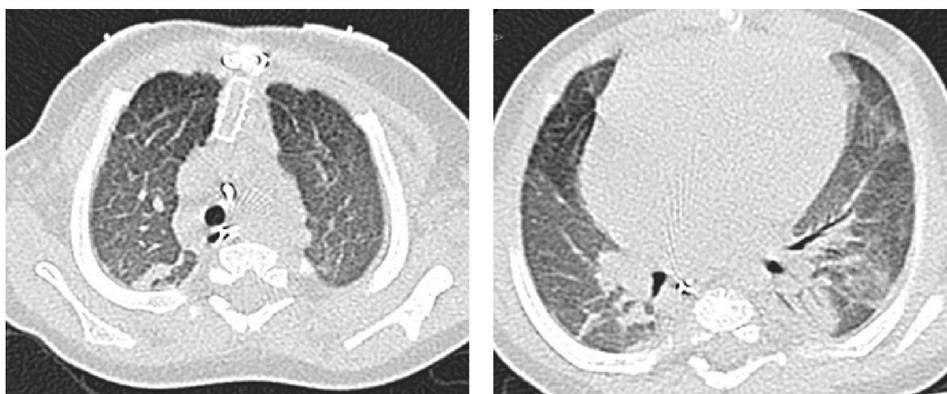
Computed tomography thorax in Case #2. Ground glass opacities characteristic of amiodarone induced pulmonary toxicity on POD #146.
